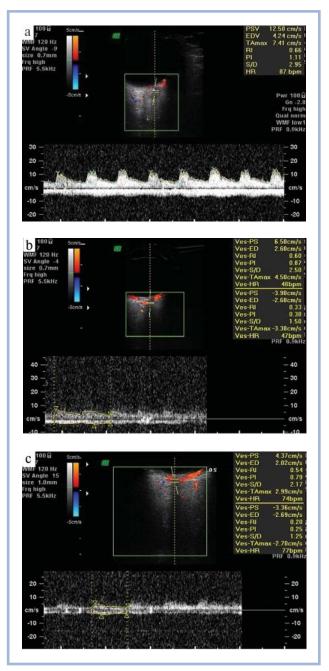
Doppler spectrum of blood flow in the CRA and CRV.
